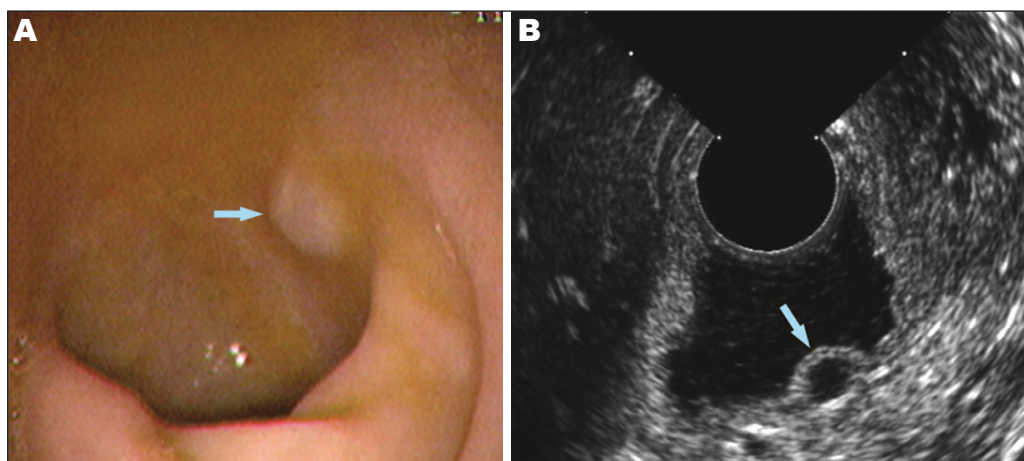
A: Endoscopic view showing a smooth protrusion in the duodenum; B: Endoscopic ultrasound showing an anechoic structure in the third layer, without internal color Doppler signal detected.
